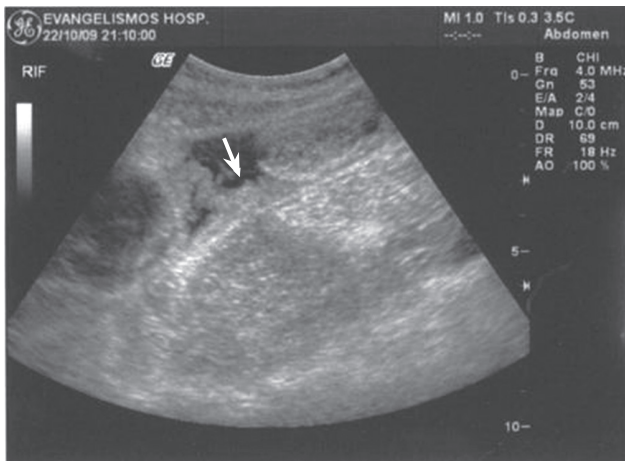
Abdominal ultrasound imaging revealed ascites with solid echogenic components (arrow).
